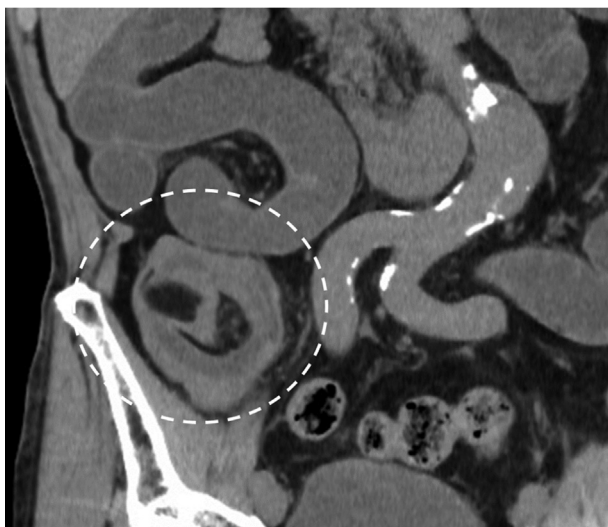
CT scan showed a target sign at the terminal ileum, and the responsible tumor showed a homogeneous low density. The patient was diagnosed with adult intussusception secondary to a lipoma in the ileum.
